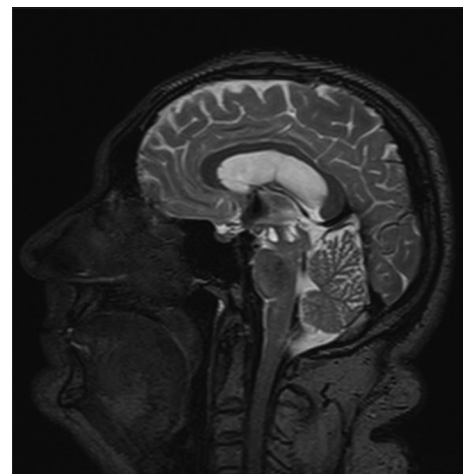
Postoperative magnetic resonance imaging sagittal T2-weighted sequence demonstrating decompression of cystic perivascular spaces and resolving distention of the third ventricle
